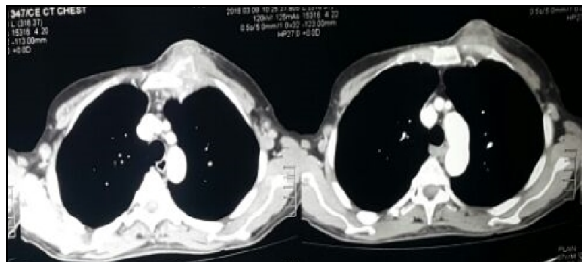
CT scan chest (axial view) showing tuberculous abscess of the chest wall involving the sternum and costal cartilage
